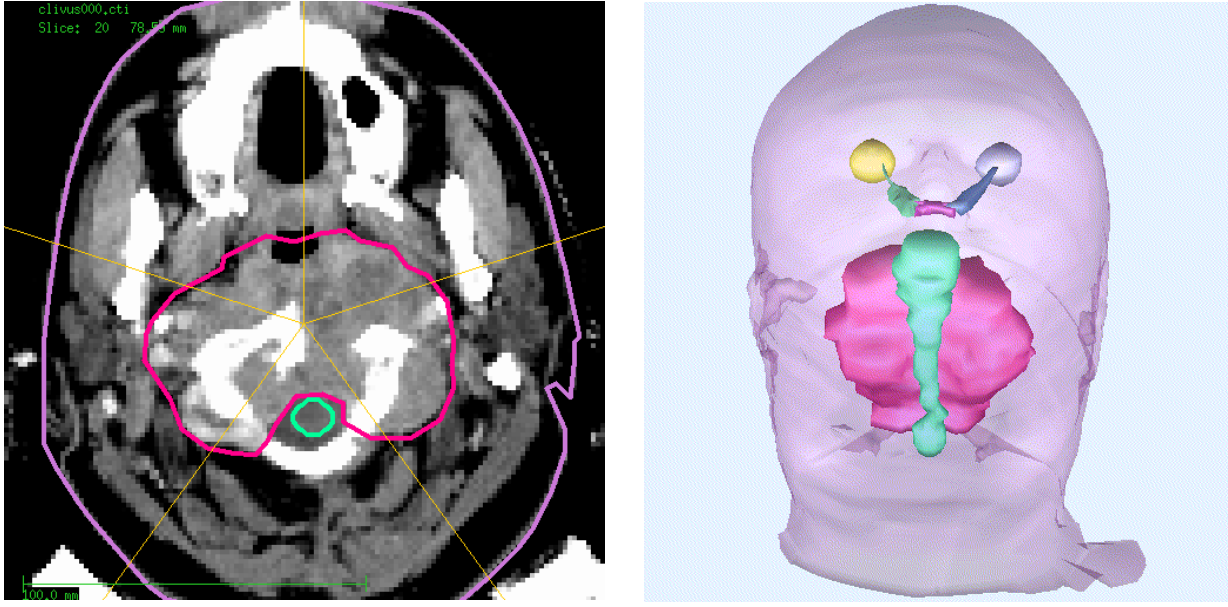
Left: Transversal CT slice through the isocentre for the patient with the clivus chordoma. The planning target volume (PTV) and the brainstem as organ at risk are indicated by the red and green lines, respectively. The five incident beam directions are given by the yellow lines. Right: Three-dimensional view of the PTV (red) and the brainstem (green) as seen from the patient's back. The eyes, the optical nerves and the chiasm are also outlined.*
